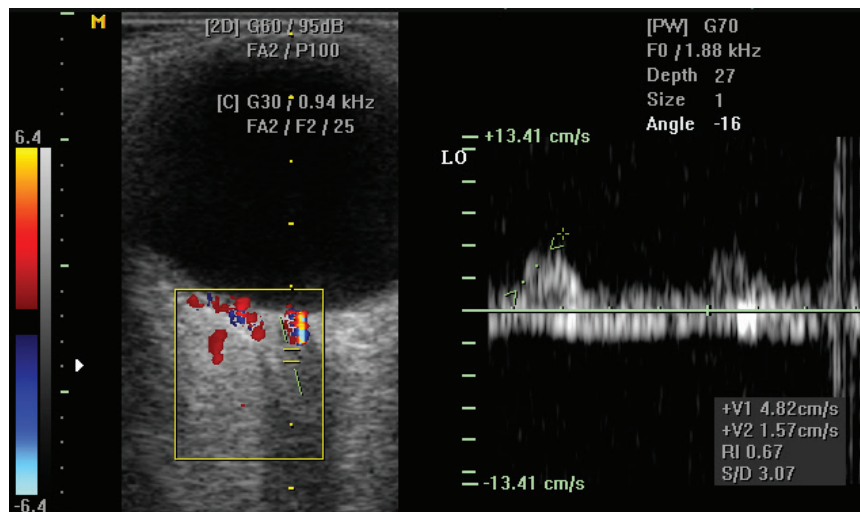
Colour Doppler ultrasonography – pronouncedly low flow parameters in central retinal artery
